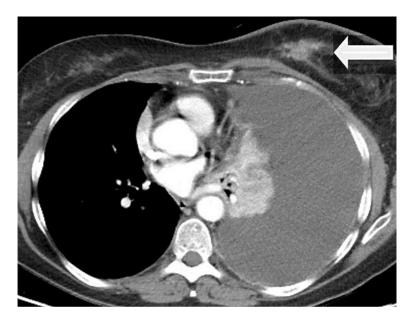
Chest CT scan. Massive pleural effusion and left breast mass (arrow).
